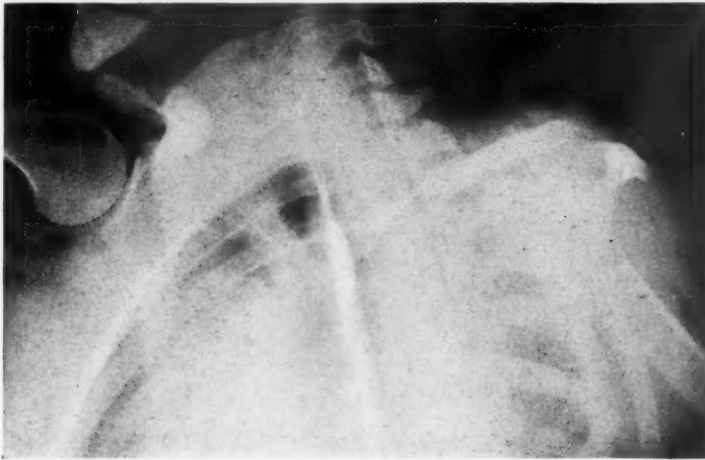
Roentgenogram of Case III. Showing cervical rib from a lateral view of the chest. The rib may be seen at the top of barium which was just passing through the esophagus.
